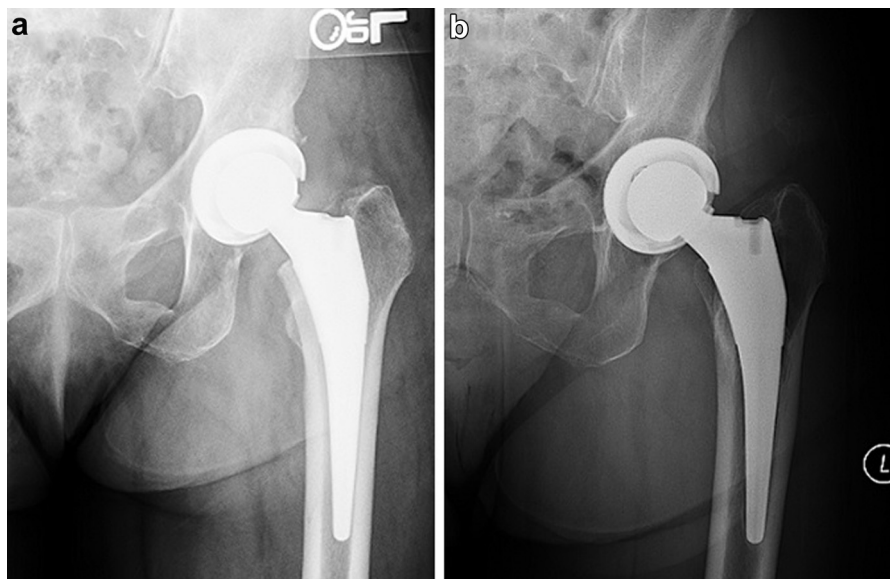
A representative AP hip radiograph from 1 of the 2 hips in which there was no evidence of radiolucency at immediate postoperative (a), but at most recent follow-up a single incomplete, radiolucent line which represented <50% of Gruen zone 5 was present (b).
